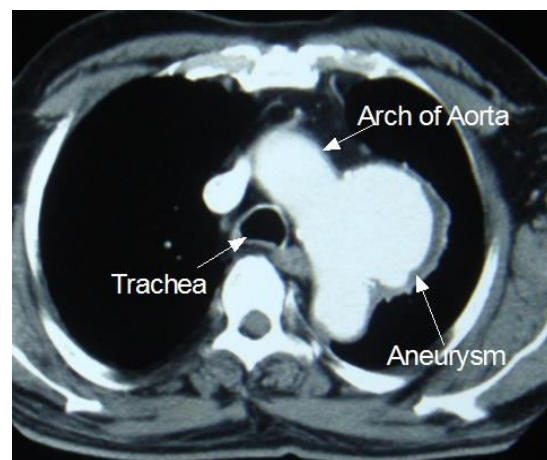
(b) Aneurysm in CT scan
